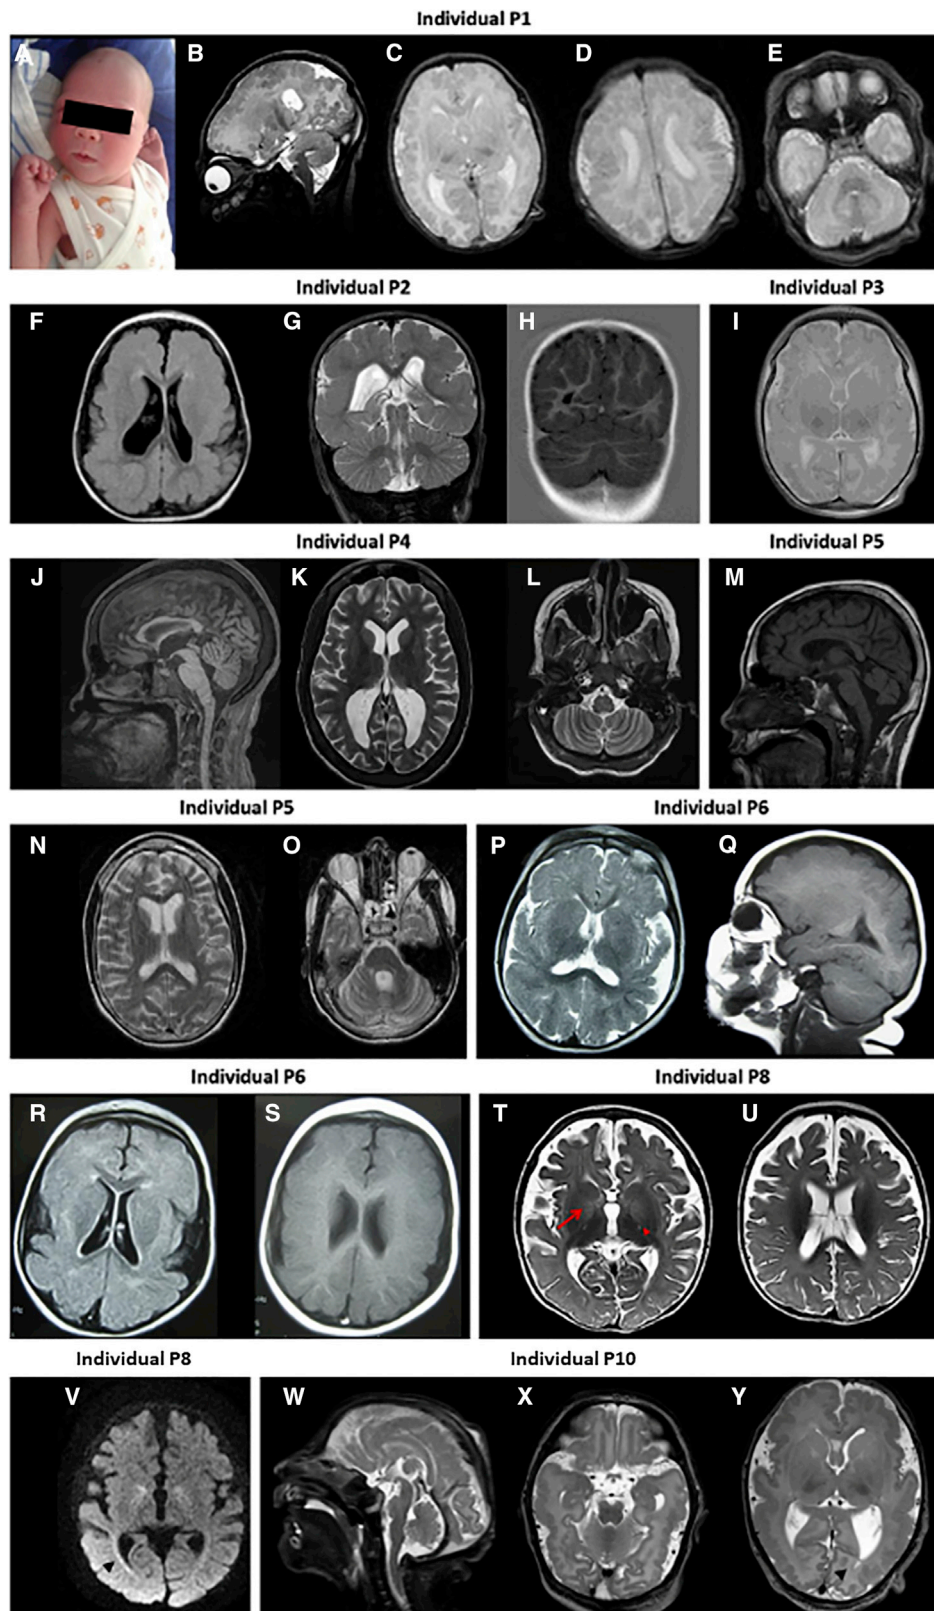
Features and Brain MRI of Individuals with *TMX2* Variants
